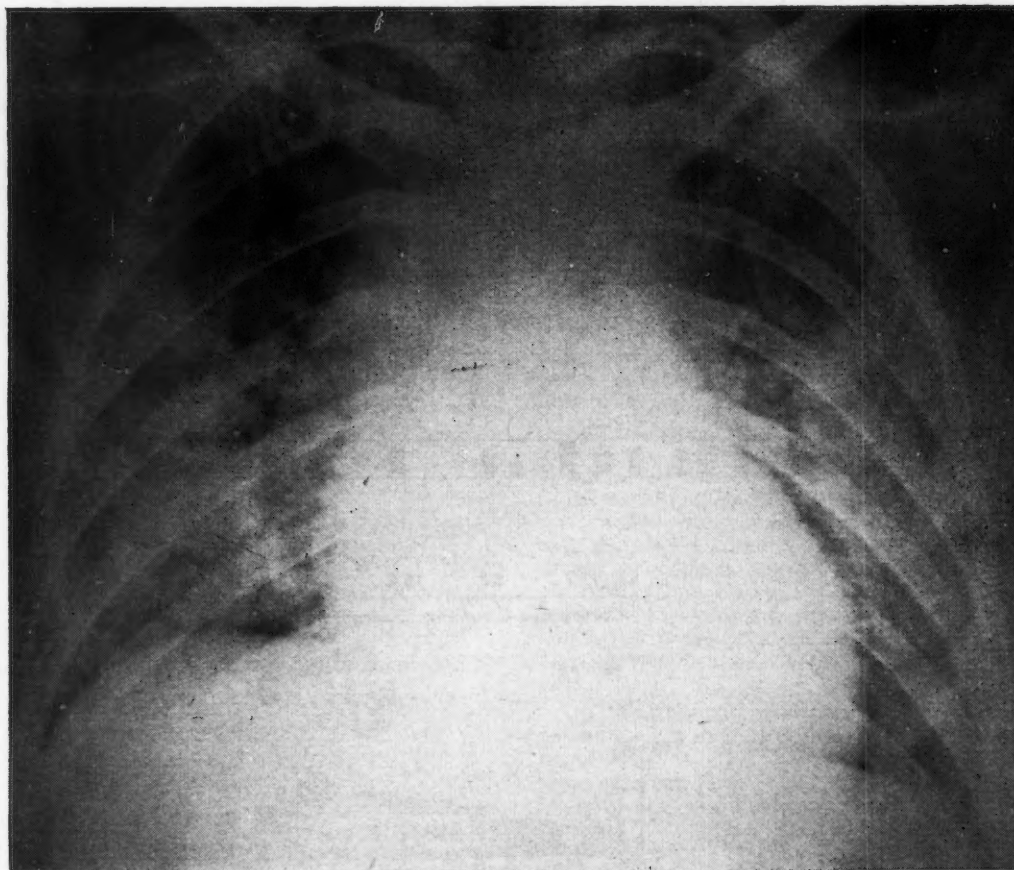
Roentgenogram of the chest taken on December 1, 1953, showing an enlarged heart and a nodular infiltration of both lower lung fields.
